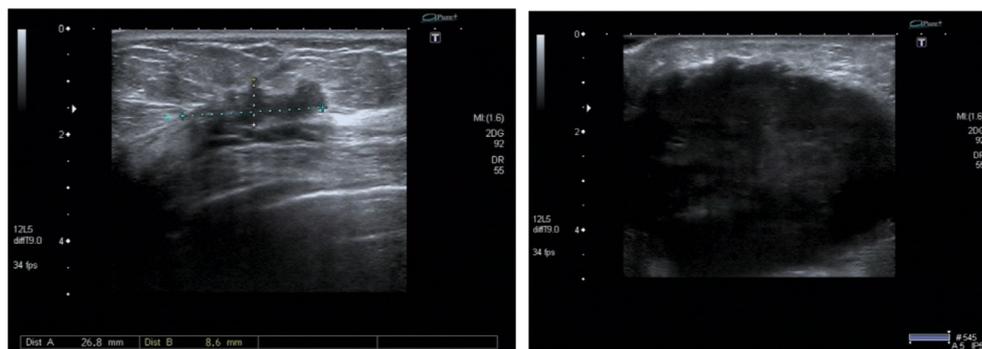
Breast ultrasonography (20 Oct 2020). Left, right breast, with a hypoechoic mass measuring 26.8×8.6 mm in the upper outer quadrant; right, the right axillary lymph node, with a hypoechoic mass measuring 79.9×42.4 mm
